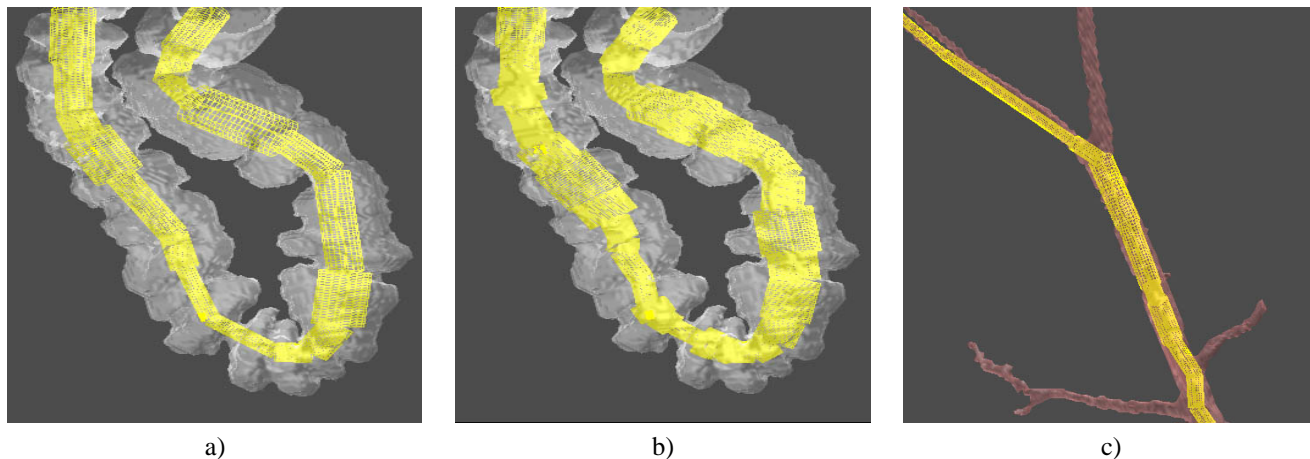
Surface of the segmented organ together with the cylindrical approximation: a) CT colon data. b) The same CT colon data as in a but using a different wall thickness. c) CT kidney data set. The segmented organ is the aorta.
